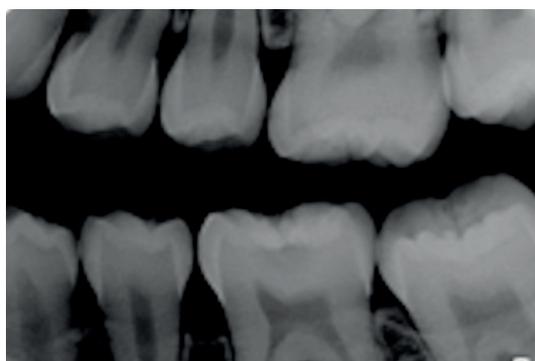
Radiographic image of an eligible molar (mandibular left first molar) to this study.
